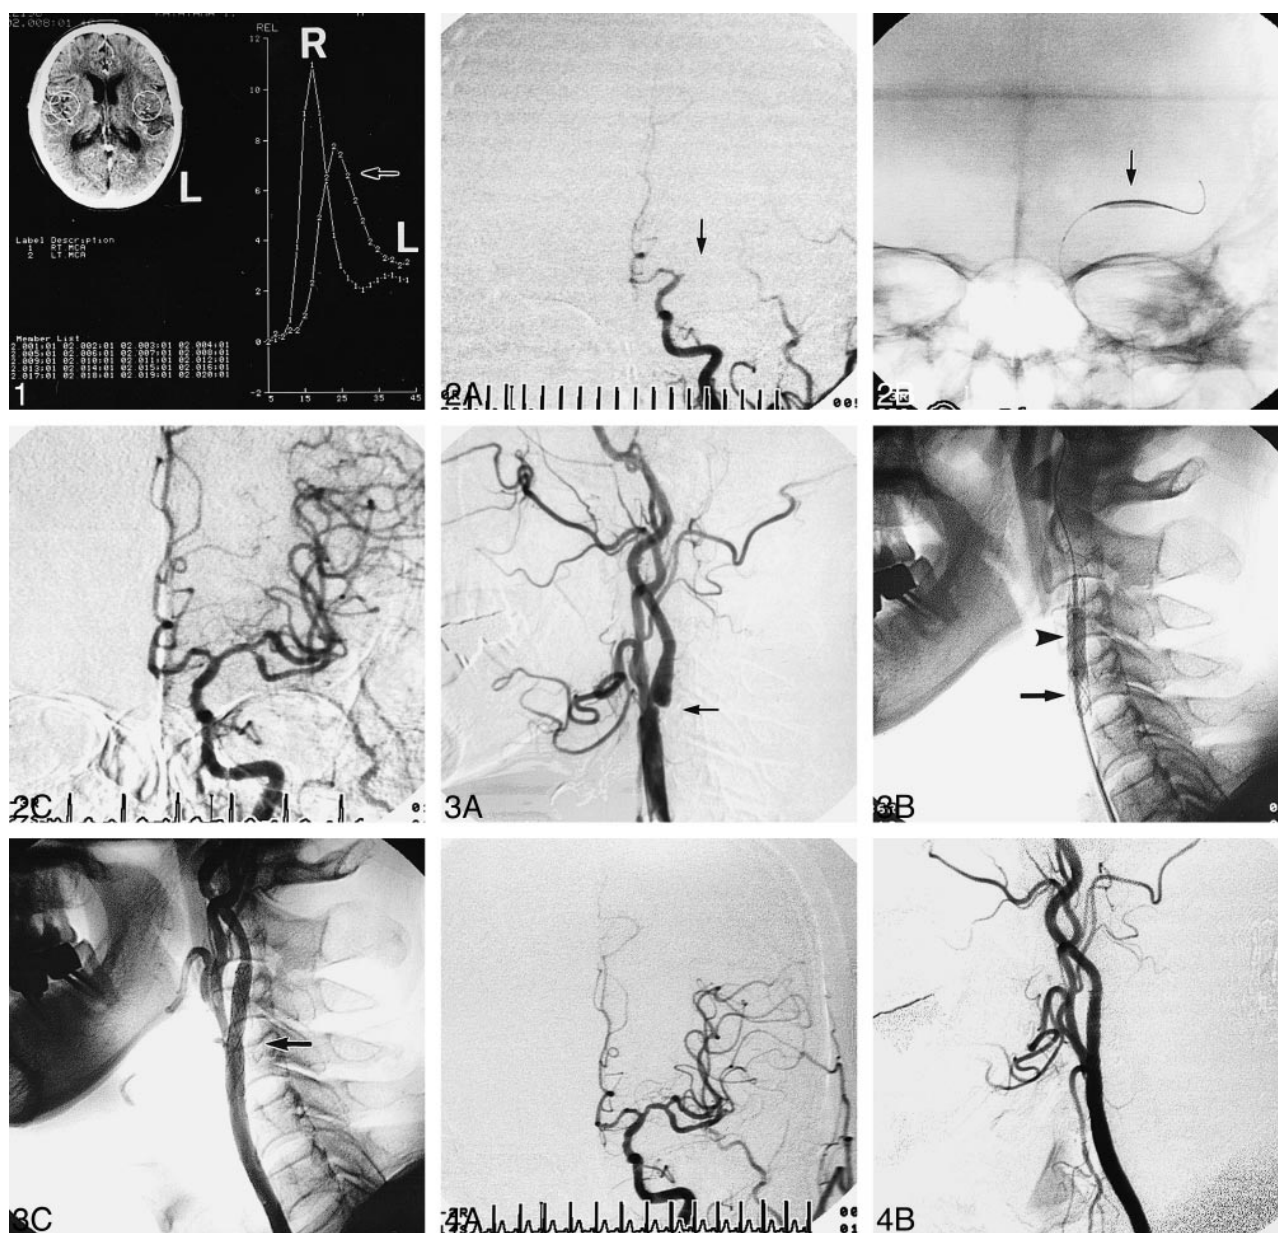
Time-density curve, calculated from dynamic CT scanning, reveals decreased flow of the left MCA (arrow) compared with the right MCA.
